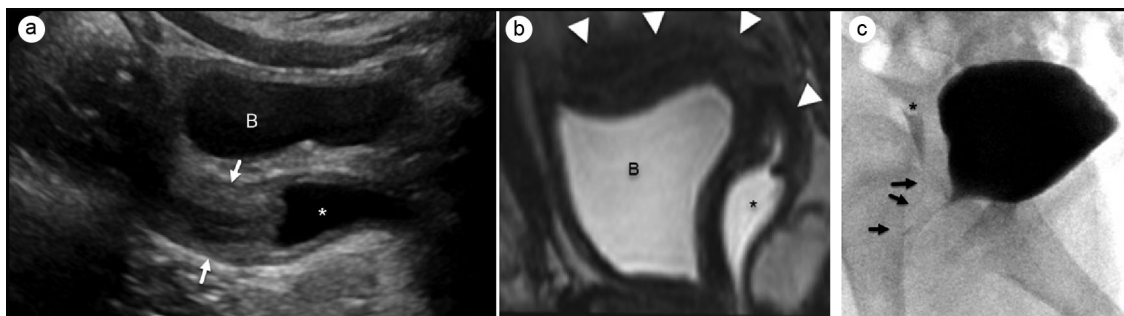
Evaluation of the intrapelvic contents at 3 months of age. (a) Initial ultrasound demonstrating a triangular fluid collection (*) posterior to the bladder (B) and adjacent soft tissue echogenicity (arrows) of indeterminate origin. (b) Oblique T2 MRI reformatted image demonstrating a rudimentary left uterine horn and cervix (arrows) accounting for the echogenicity on ultrasound, with fluid in a hemivagina (*) posterior to the bladder (B). (c) Voiding cystourethrogram near the end of voiding demonstrating communication (arrows) between the posterior urethra and hemivagina with a cervical impression (*).
